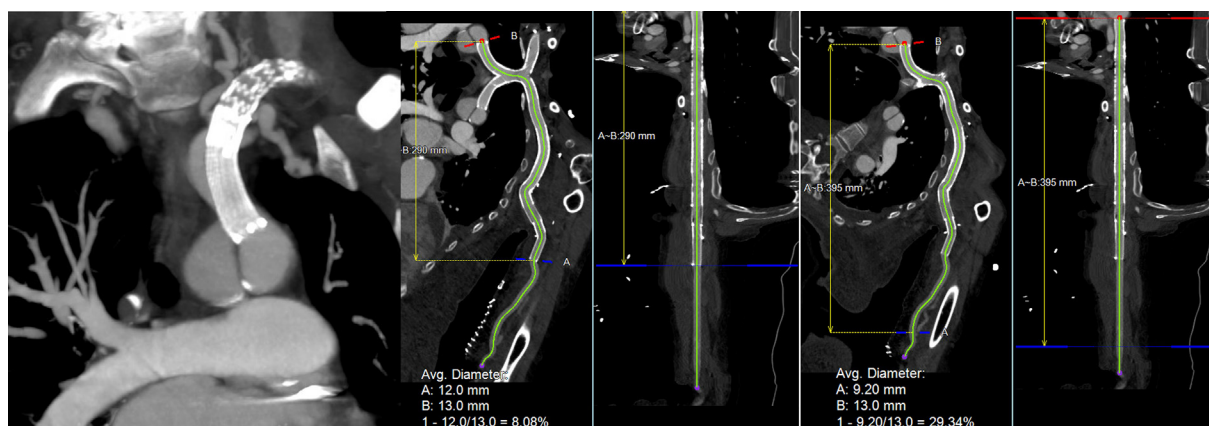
Follow-up computed tomography angiograms showing full extent of stenting over 29 cm and bypass over 39.5 cm, with a patent left internal mammary artery (LIMA) and left vertebral artery.
